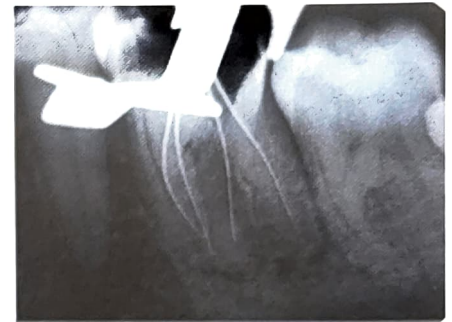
Working length X-ray
